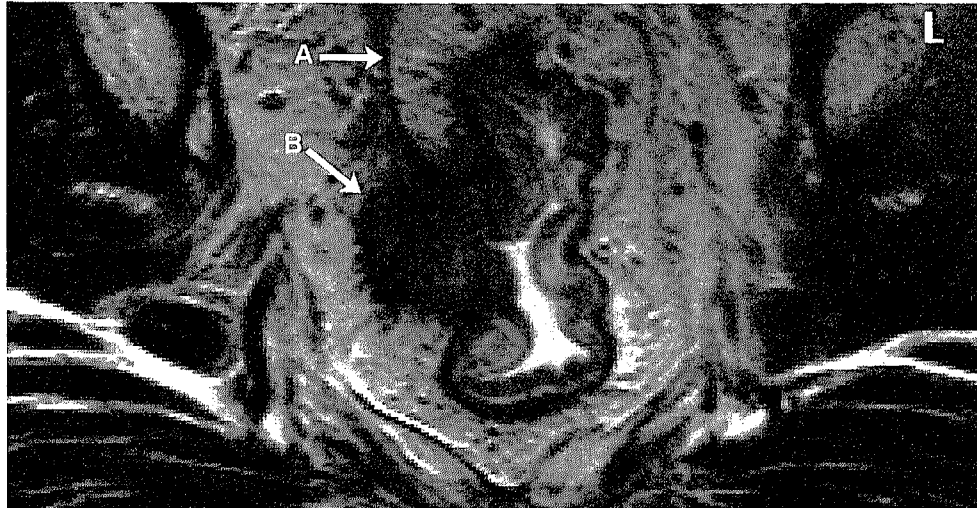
T4 rectal cancer with an obvious involved circumferential resection margin in a 45-year-old male patient. Axial T2W FSE (TR/TE 3427/150 msec) MR image shows a tumor in the rectal wall. A well visualized mesorectal fascia (A). The tumor aggressively invades the mesorectal fascia and invades deep in the extramesorectal tissue (B).
